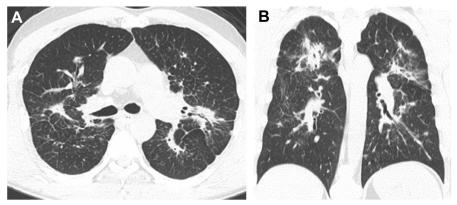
Axial and coronal HRCT images of chronic beryllium disease, with upper lung predominant fine nodularity with septal thickening and peribronchovascular coalescent nodules.
